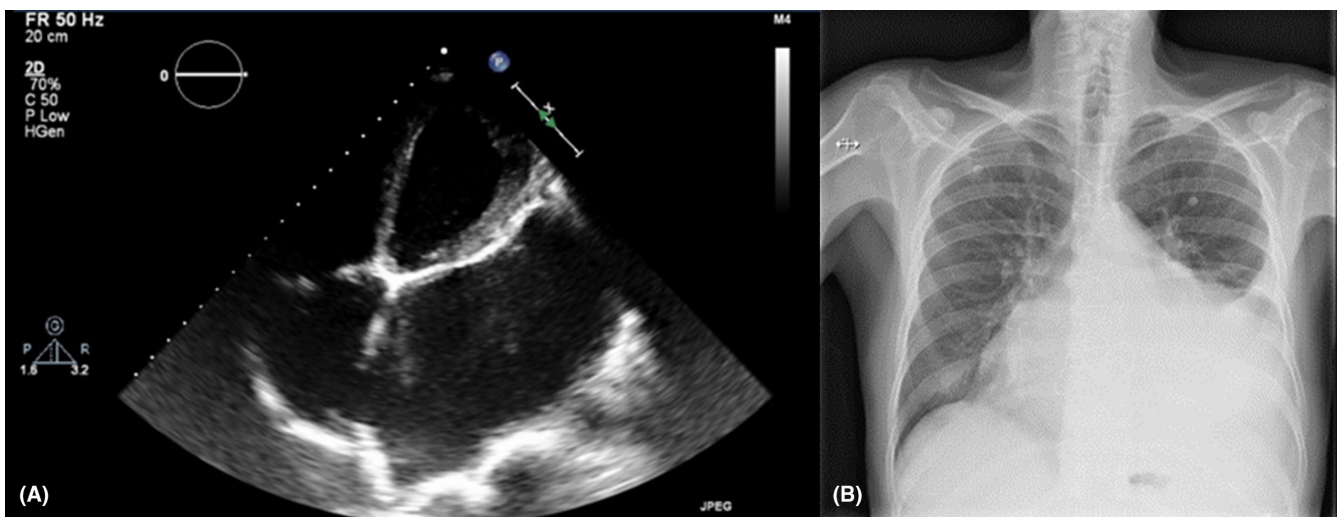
(A left) Apical four chamber view in transthoracic echocardiogram showing aneurismatic dilation of the left atrium, severe dilation of right atrium and mild dilation of the right ventricle, with normopositioned mitral and tricuspid prosthetic rings; (B right) Chest radiograph revealing a significant elevated cardiothoracic index and large left pleural effusion
